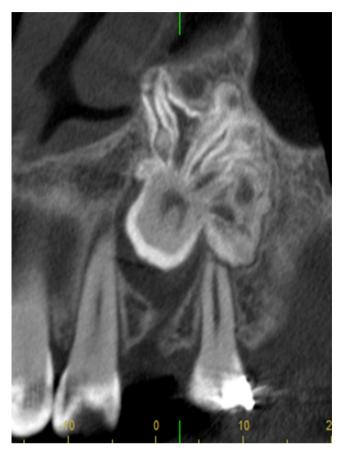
CBCT sagittal image demonstrating the root area of #11 possessing multiple octopus leg-like branches, with each "leg" exhibiting all three distinct enamel, dentin, and pulp densities.
